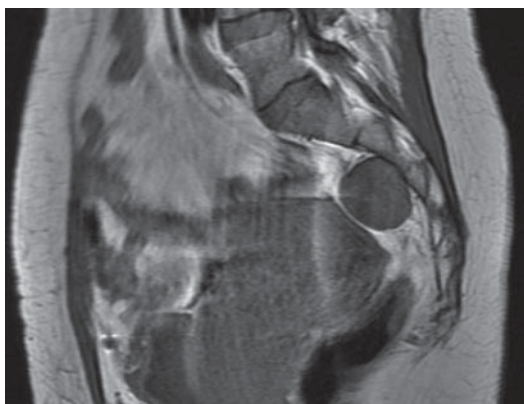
MRI of presacral schwannoma showing well-circumscribed homogeneous mass.
